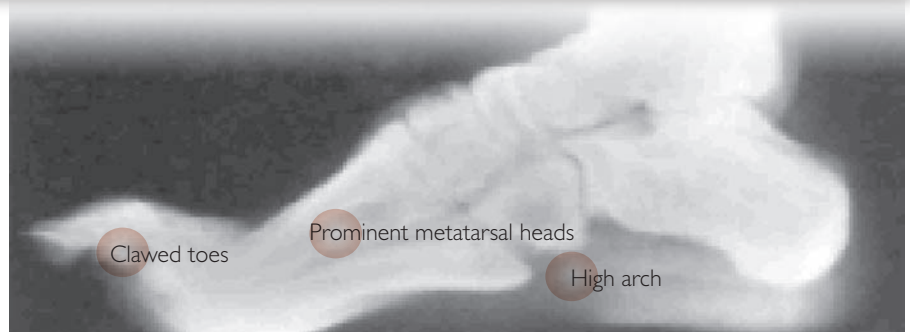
Classic structural change in the foot due to motor neuropathy as seen on X-ray.
